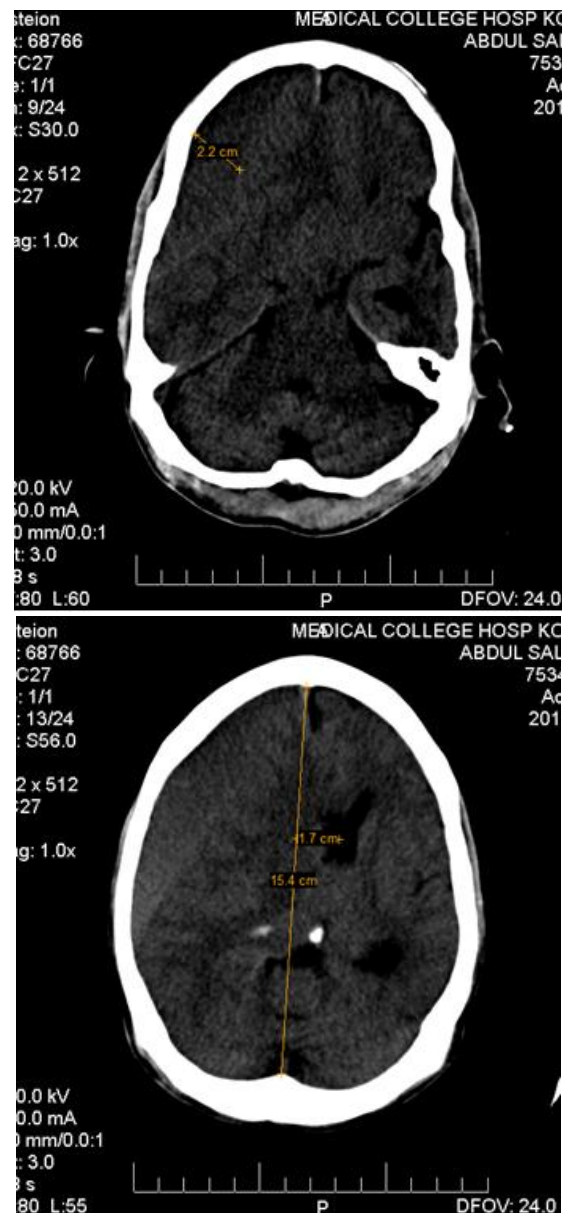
This patient came with GCS score of 8 and underwent initial CT scan within 3-6 hours. CT revealed acute SDH of thickness 22mm in right fronto-parieto-temporal region with midline shift of 17 mm, compressed basal cisterns and 3 tiny contusions in left parietal lobe. Rotterdam score was 4. Patient was discharged in 2 weeks and had poor outcome (severe disability) at the time of discharge and after 3 months follows up.
